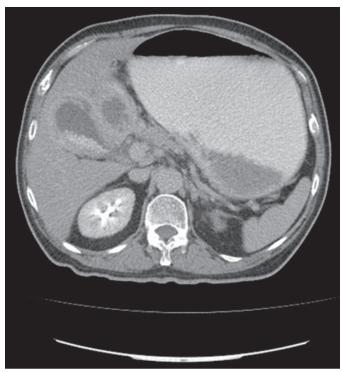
Triple phase computed tomography scan of abdomen and pelvis with gallbladder wall thickening suggesting gallbladder carcinoma.
